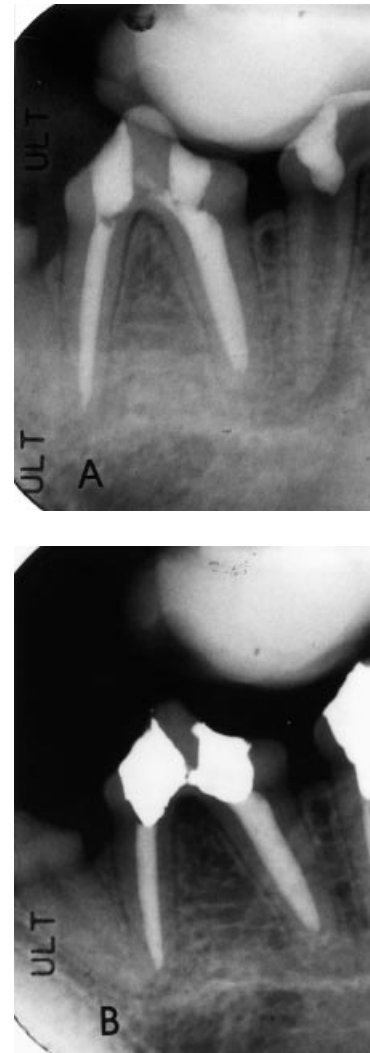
Radiographic follow-up of negative control (vital pulpectomy). (A) Immediate postop; (B) six-month follow-up.
